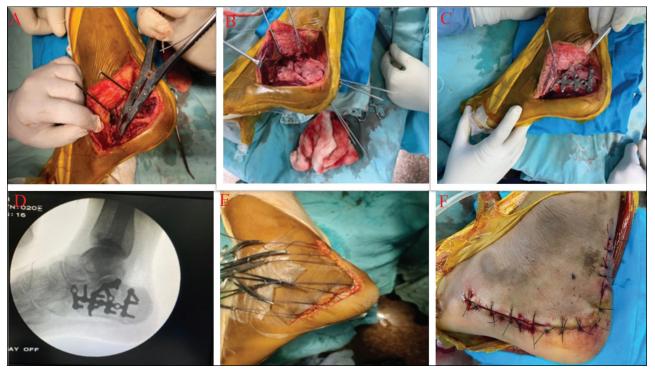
Reduction and internal fixation of the calacaneal fracture. (a) de-roofing of lateral wall completed with bone nibbler, (b) provisional internal fixation with K-wires after confirmation of reduction, (c) definitive fixation with locking plate, (d) intraoperative radiograph showing satisfactory fracture reduction with restoration of radiographic parameters, (e and f) closure with Allgower–Donati sutures
